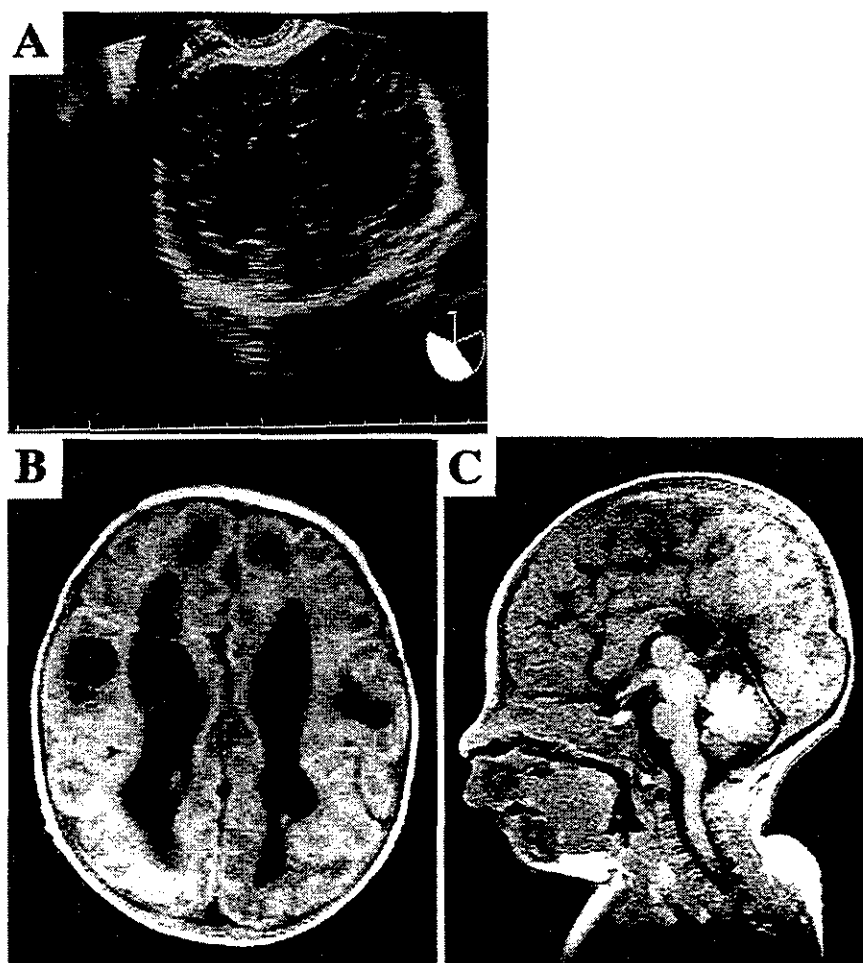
Enlargement of the lateral ventricles of the fetus was reconfirmed by ultrasonography at the 32nd week of gestation (A). T1-weighted magnetic resonance imaging of the brain recorded at 1 month of age revealed atrophic change of the cerebrum with multiple cystic changes in the brain substance, formation of the intraventricular septum, enlargement of the posterior horns of the lateral ventricles (B), atrophy of the brainstem, and partial agenesis of the corpus callosum (C).
